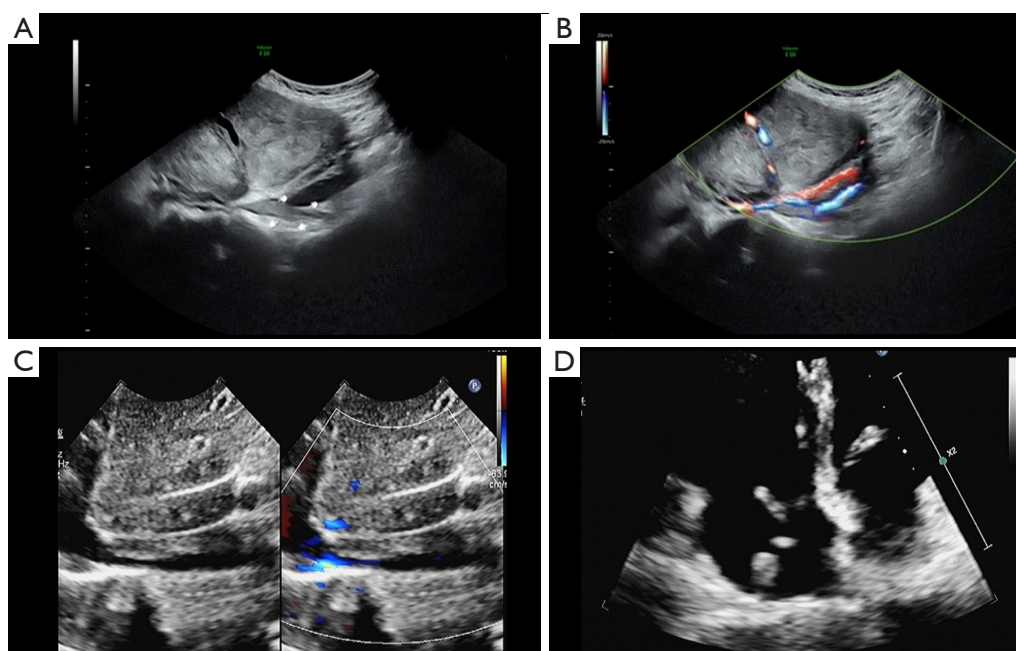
Conventional ultrasound and color Doppler ultrasound findings of IVL. (A) A large hypoechoic mass measuring approximately 20.6 cm in length was visible on the right side of the uterus. It closely adhered to the right uterine wall, and within the right internal iliac vein, there were hypoechoic mass (indicated by the small hand symbol). (B) CDFI showed blood flow filling defects within the right internal iliac vein. (C) Longitudinal section of the inferior vena cava displayed hypoechoic mass extending along the venous lumen. CDFI depicted fine blood flow bundles between the hypoechoic mass and the venous wall. (D) A cord-like hypoechoic structure was visible in the right atrium, continuous with the hypoechoic mass in the inferior vena cava. It exhibited movement with the cardiac cycle, partially passing through the tricuspid valve into the right ventricle during diastole. CDFI, color Doppler flow imaging; IVL, intravenous leiomyomatosis.
